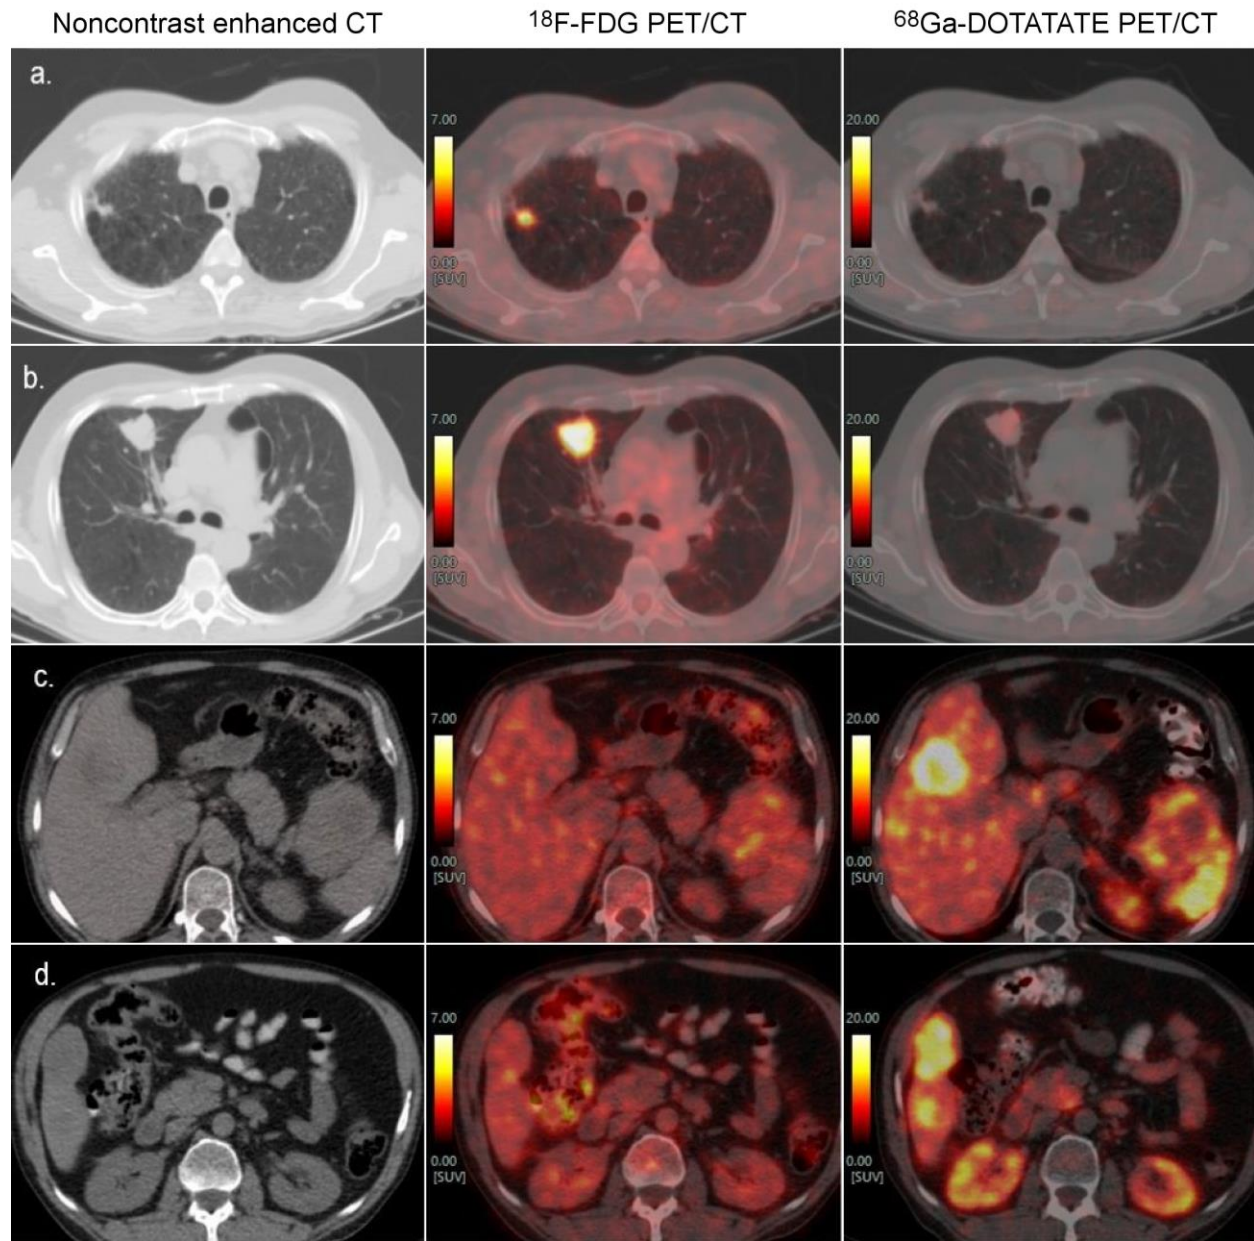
Follow-up dual tracer PET/CT (non-contrast CT, ^{18}F -FDG fused transaxial images and ^{68}Ga -DOTATATE fused transaxial images) showing FDG avid (SUVmax:10.9) and non-SSTR expressing (SUVmax:4.7) lung lesions in right upper lobe (a. and b.); non-FDG concentrating (SUVmax:2.8) and highly SSTR-expressing hypodense segment V lesion in the liver (SUVmax:29.4) and nodal mass at splenic hilum (c.) and similar non-FDG concentrating (SUVmax:2.4) highly SSTR-expressing hypodense segment VI lesion in the liver (SUVmax: 26.5).
